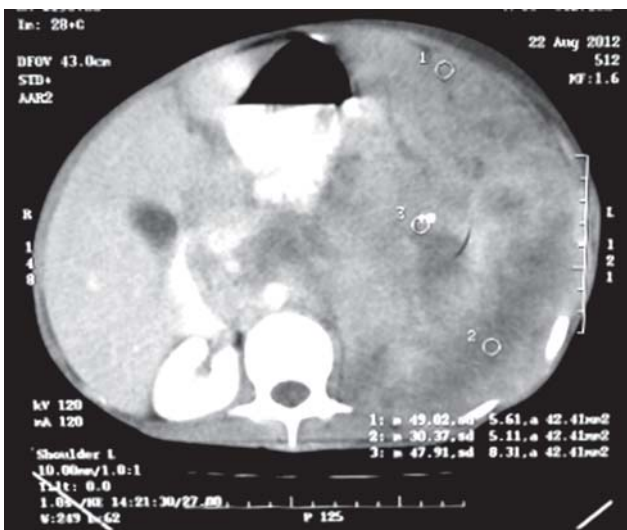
Computed tomography of the abdomen showing left-sided intra-abdominal mass shifting other structures to the right.
